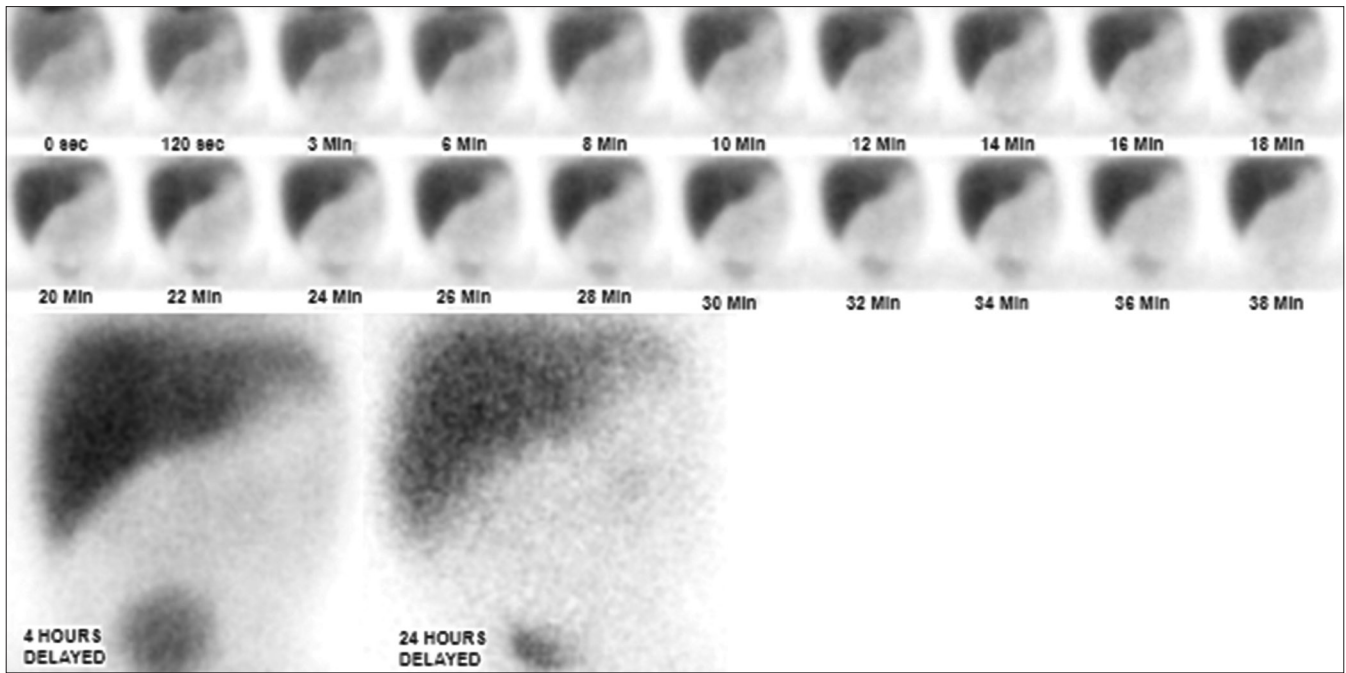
A 2-month-old female child presented with complaints of yellowish discoloration of eyes since birth and passing clay-colored stools. Total bilirubin was 14.5 mg/dL. Direct bilirubin was 2.1 mg/dL. Alkaline phosphatase and gamma-glutamyl transferase levels were 2525 U/L and 709 IU/L, respectively. Ultrasonography revealed the presence of dilated intrahepatic bile ducts. Dynamic images of the abdomen mildly impaired tracer uptake in the liver – suggestive of mildly impaired hepatic tracer extraction (upper and middle rows). Intrahepatic bile ducts, gallbladder, and common bile ducts are not visualized in the dynamic images. Serial static images of the abdomen and pelvis acquired up to 24 h (lowermost row) show persistent retention of tracer in the liver – suggestive of impaired hepatic excretion. Gallbladder and small intestines were not visualized up to 24 h. A final diagnosis of biliary atresia was made on the basis of liver biopsy and intraoperative cholangiography
